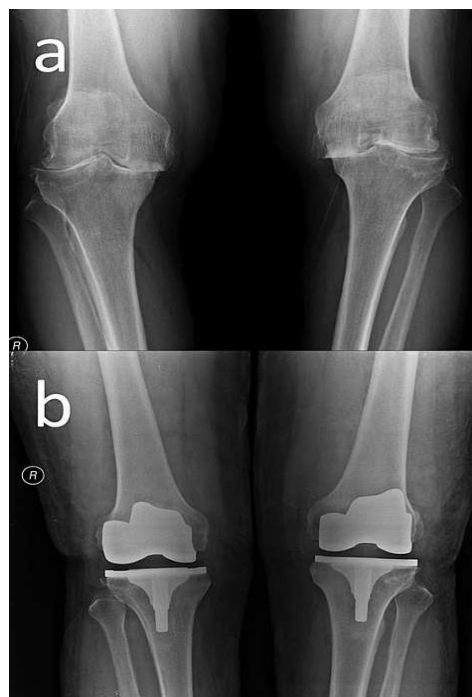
Preoperative and postoperative bilateral knee radiographies of the patient
